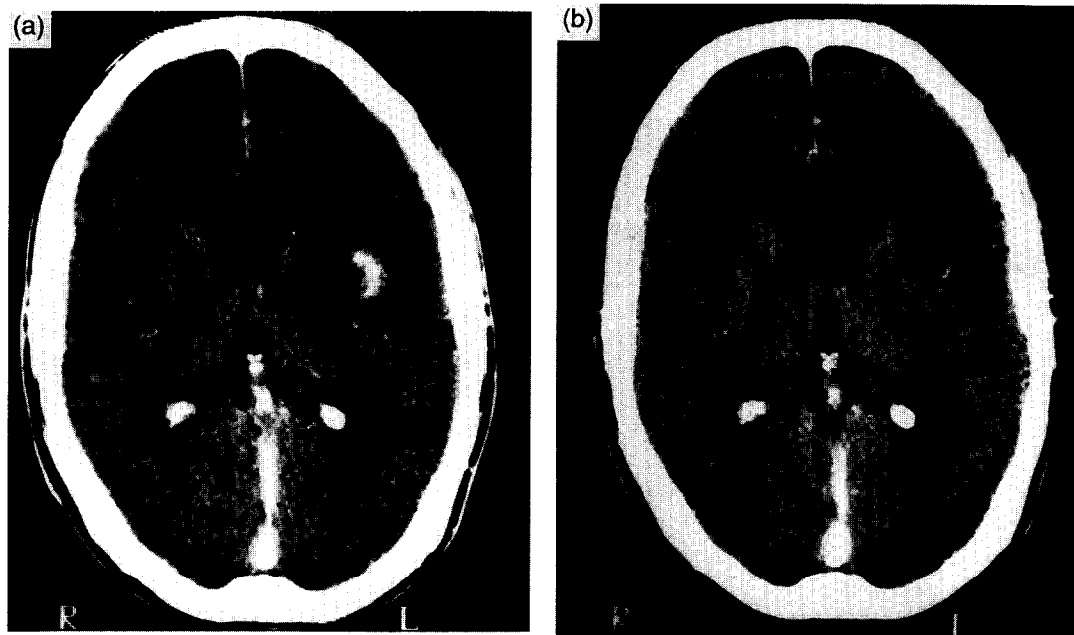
(a) CT scan of a patient with an anaplastic glioma at recurrence; (b) CT scan after one cycle of ICE. The complete response was maintained for 82 weeks.
